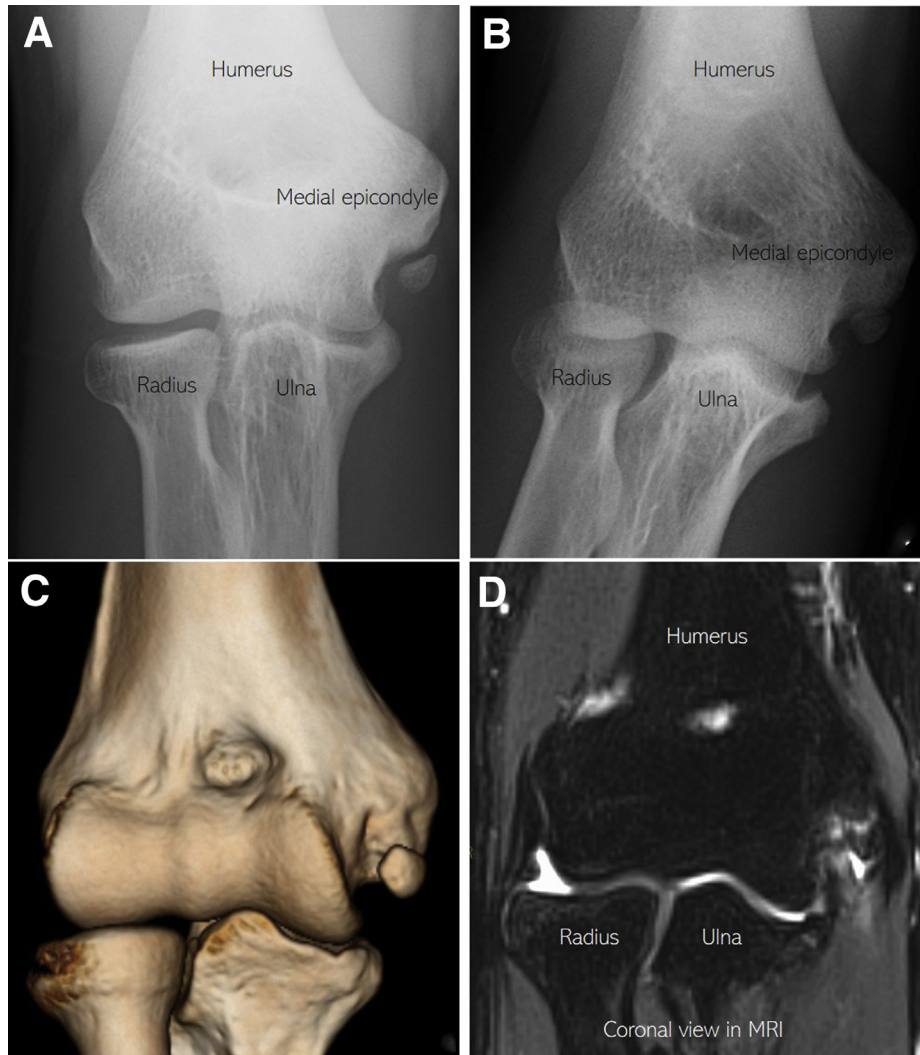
(A) A plain radiograph of the elbow (AP view) of a 20-year-old baseball player who presented to our hospital with complains of right elbow pain of 5 years' duration with chronic right elbow pain and valgus instability. It shows a bony fragment along with the medial epicondyle, suggesting Little League elbow. (B) Valgus stress AP view shows valgus instability of the elbow joint. (C) A 3-dimensional computed-tomography scan shows the fragment of the medial epicondyle of the humerus. (D) Magnetic resonance imaging T2 fat suppression coronal view shows a high-intensity area surrounding a round/circular area of low intensity suggestive of a bony fragment with the UCL detached from the medial epicondyle.
